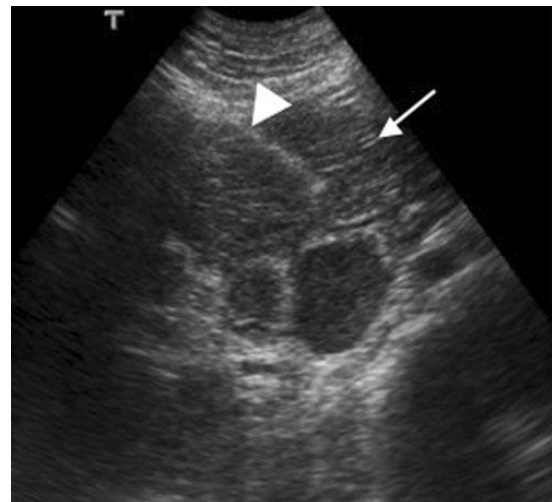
A 29-year-old patient with rejection of the pancreatic graft after SPK transplantation. Ultrasound-guided biopsy of the pancreatic graft (arrowhead needle biopsy). Pancreatic graft (arrow) shows normal size but with heterogeneous texture of the parenchyma
